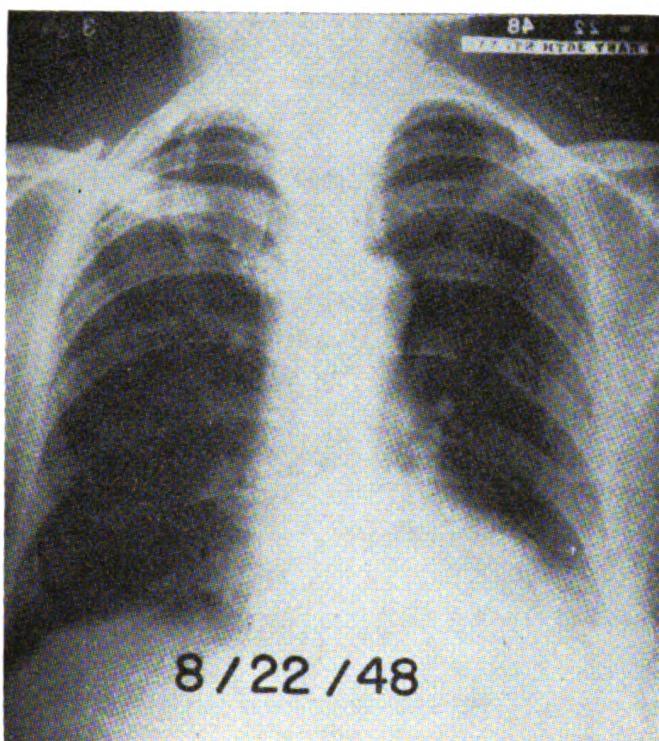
Anteroposterior view of chest in Case E.H. at conclusion of testosterone and deep X-ray therapy to spine, showing destruction of medial $\frac{1}{3}$ of left clavicle and metastatic rib lesions.
